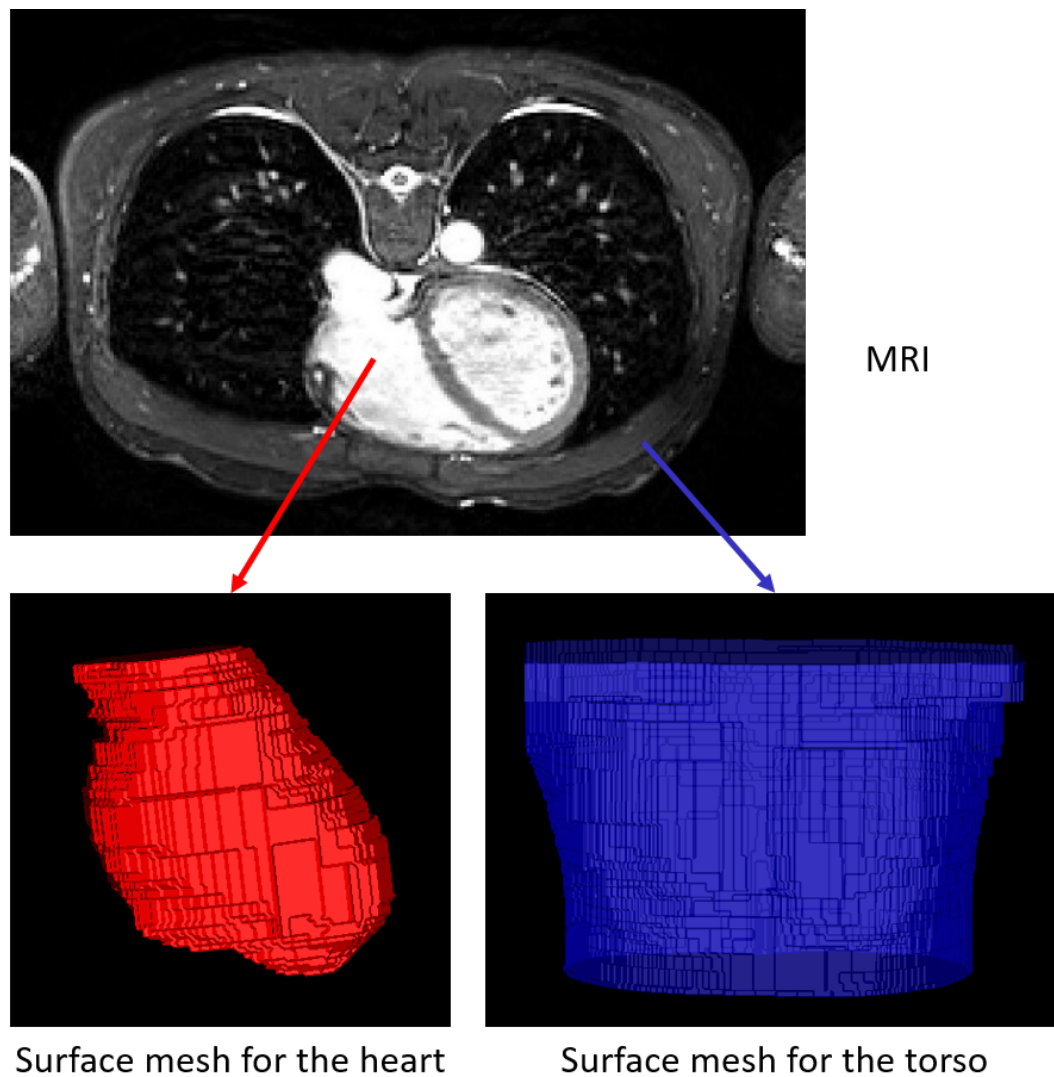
Segmented torso and heart meshes for the first model. The top image is an MRI slice used to segment layers or regions of interest. The left image in red is the heart mesh model, and the right image in blue is the torso mesh model.
